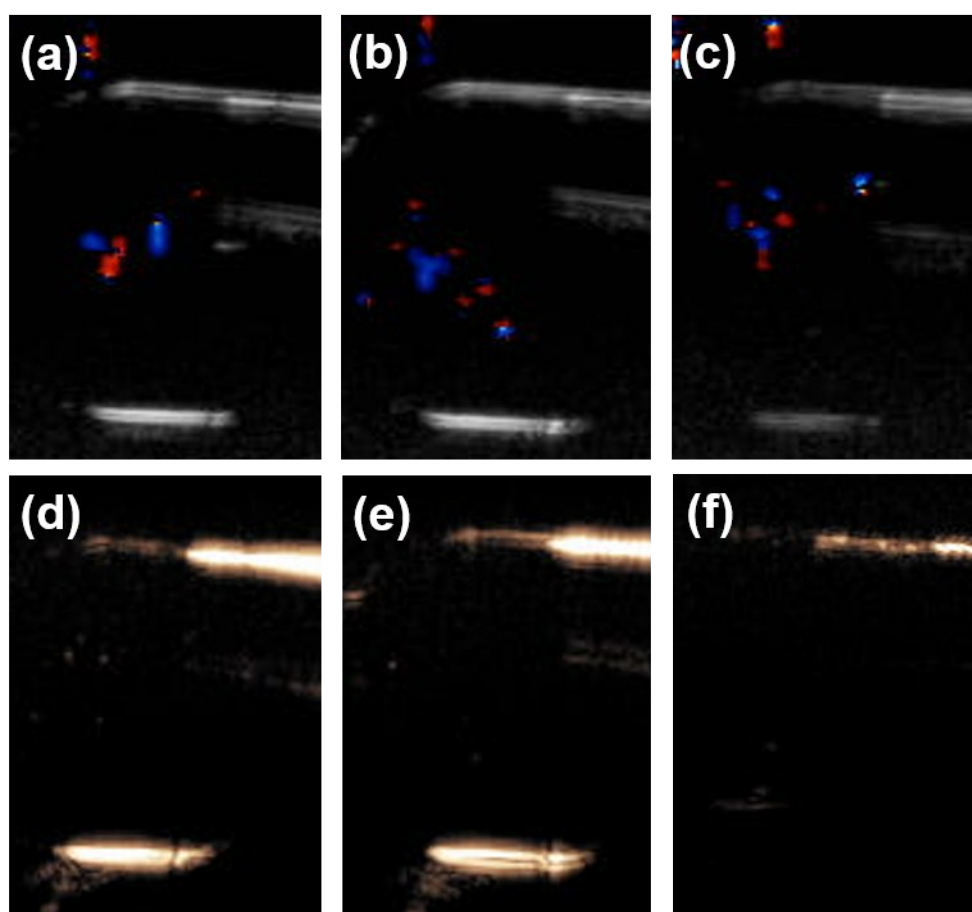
Color Doppler imaging of (a) PDA-74, (b) PDA-174, and (c) PDA-350; CPS imaging of (d) PDA-74, (e) PDA-174, and (f) PDA-350 at MI=1.9 in aqueous solution without PFP treatment.
